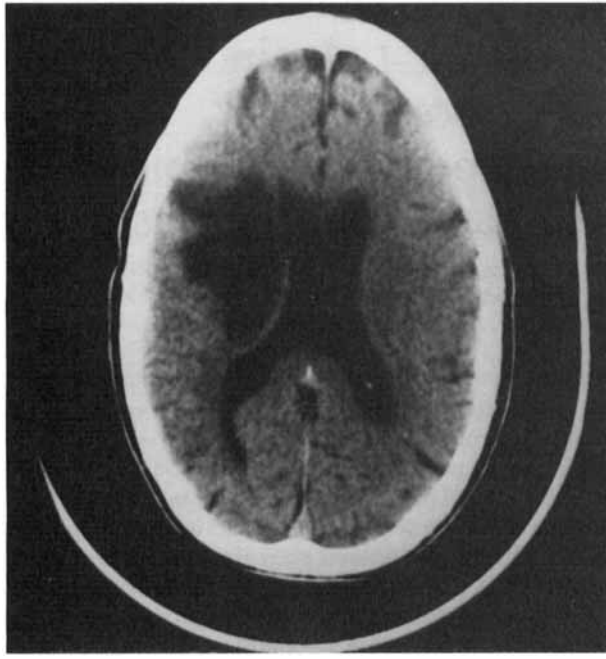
Computed tomograph of Patient 1 one week after presentation. Patient's right is viewer's left.
